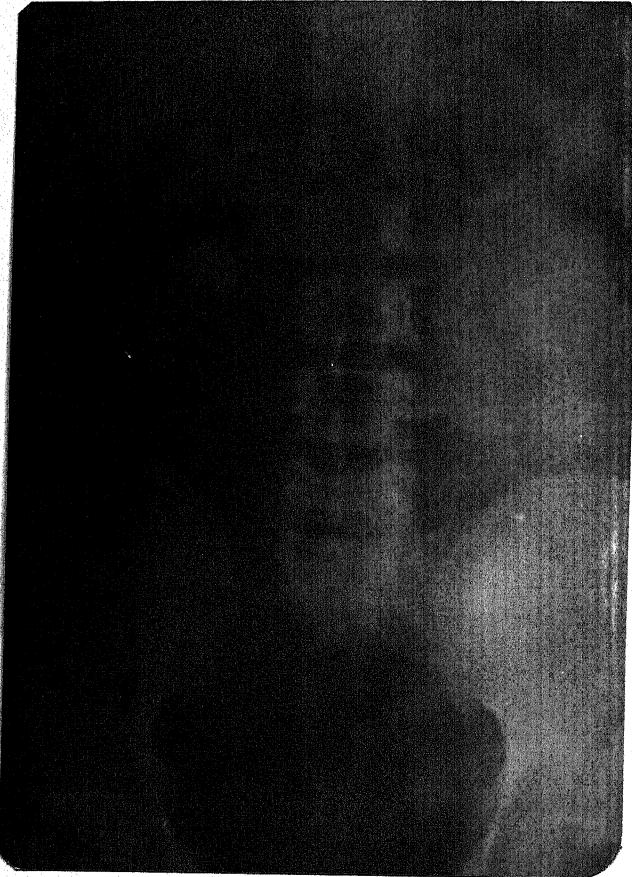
PLAIN RADIOGRAPH SHOWING
